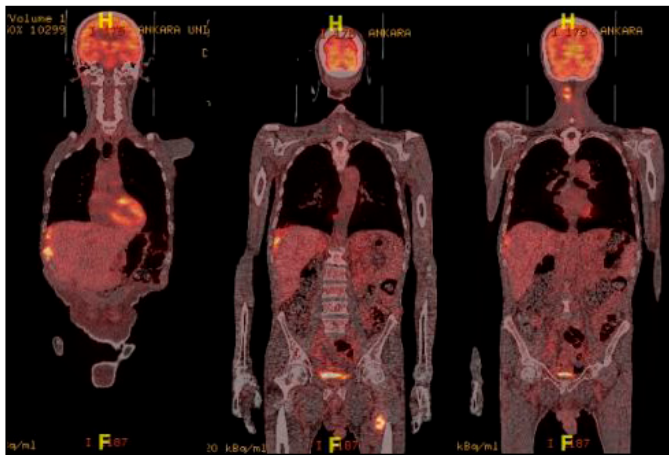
Antibiyoterapi öncesi FDG-PET/CT
